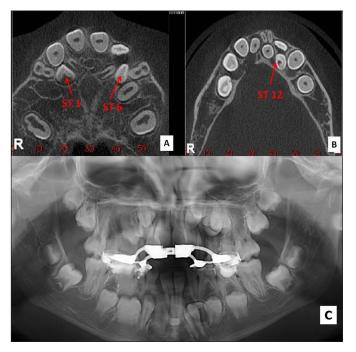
Postsurgical CBCT showing the remaining 2 supernumerary teeth in the maxilla (A) and 1 in the mandible (B). Panoramic radiograph view taken 2 years later (C).
